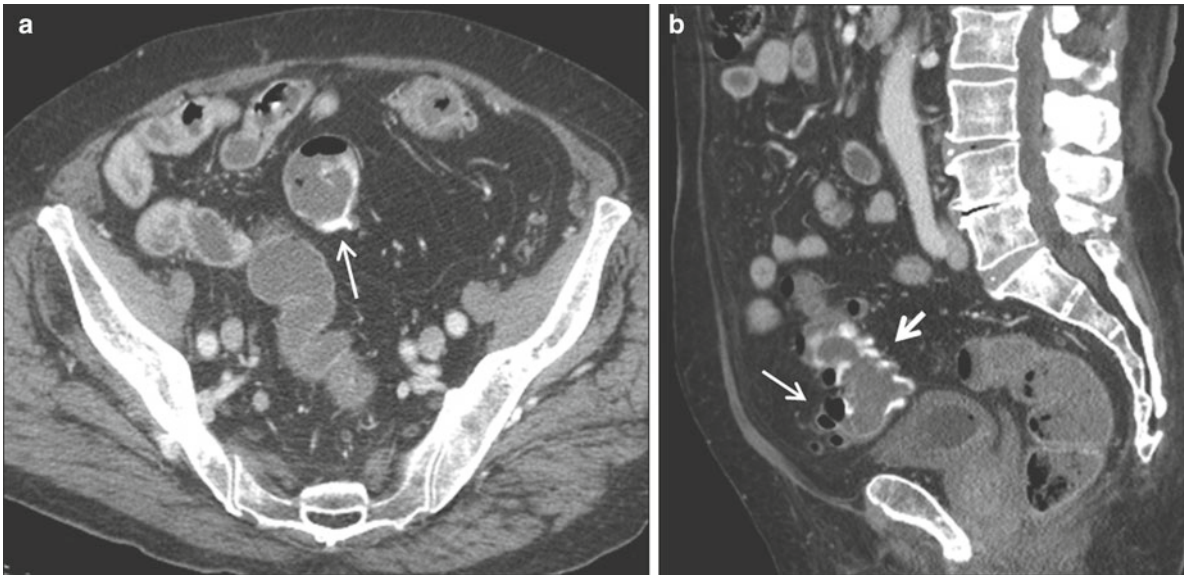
CTA showing acute GI bleed in elderly patient. (a) Axial image showing contrast pooling in the lumen of the sigmoid colon (*arrow*) from bleeding diverticulum. (b) Sagittal reformation showing several diverticula (*thin arrow*) and contrast pooling in the lumen (*thick arrow*)
